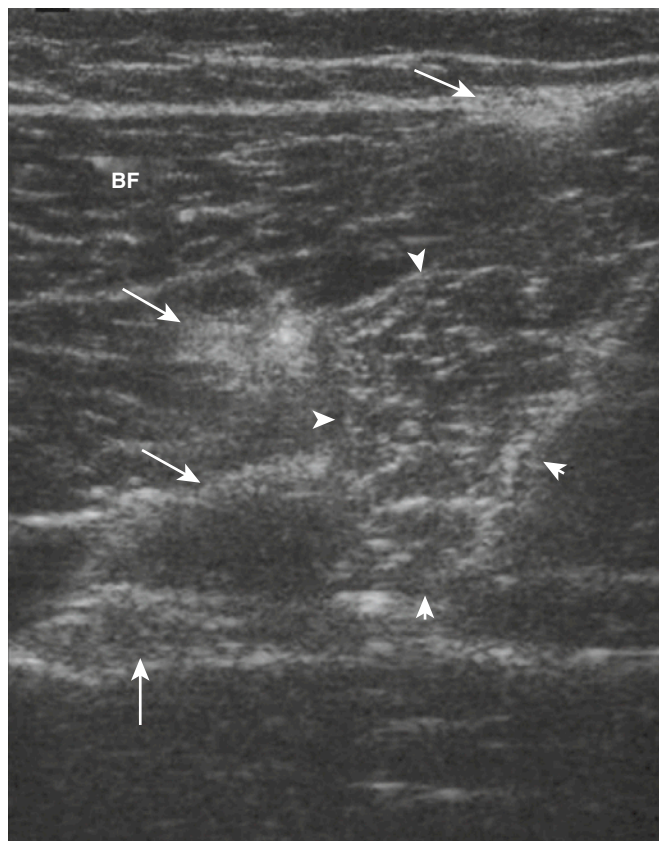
Grade 1 muscle strain and previous scarring. Transverse sonogram of the posterior thigh shows the biceps femoris (BF) with three areas of echogenic scar tissue (*oblique arrows*). Adjacent to this, an area of acute muscle edema (*arrowheads*) is consistent with a low-grade 1 acute injury. Notice the adjacent sciatic nerve (*vertical arrow*).
